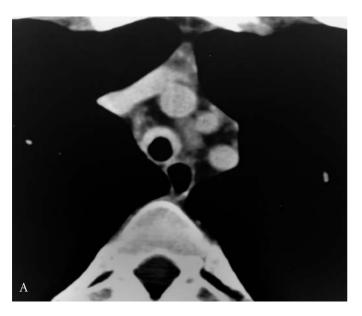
Relapsing polychondritis. Computed tomography scans demonstrate diffuse thickening of the trachea (A) and bronchial (B) cartilages.
